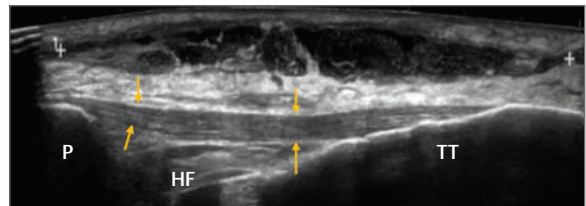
Longitudinal image of the infrapatellar region of the knee in a patient who had sustained a fall onto the knee 10 days prior to examination. The patella tendon (yellow arrows) appears intact, however, there is a large low echo swelling measuring approximately 9 cm in length (white crosses) superficial to the patellar tendon within the subcutaneous tissue. With Power Doppler, there was no associated increase in vascularity. These findings are indicative of a subcutaneous posttraumatic hematoma. HF, Hoffa's fat pad; P, patella; TT, tibial tuberosity; white arrowheads, prepatellar bursitis; white crosses, subcutaneous hematoma.
